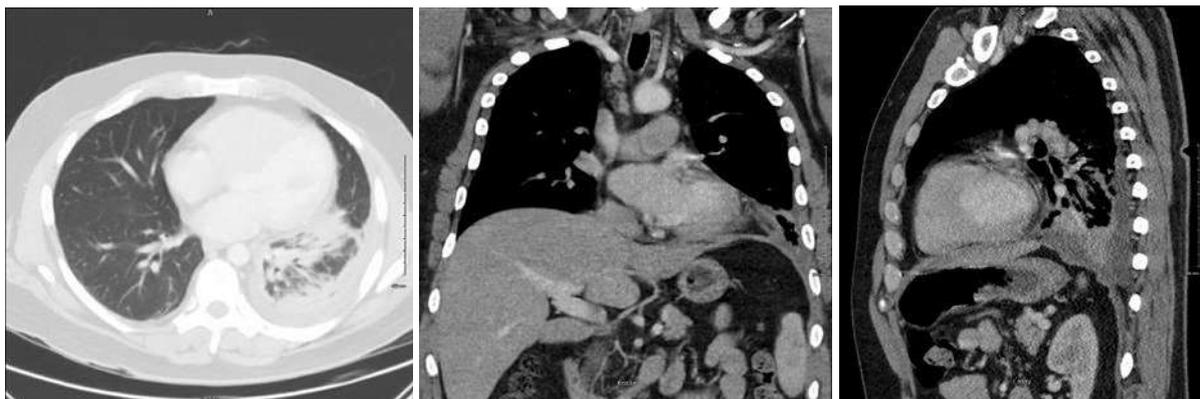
4B and 4C: Chest CT done after drainage - transverse, coronal and sagittal views - Interval near complete drainage of the cavitory lesion in the left lung base. Small residual thin curvilinear cavity remains. Airspace opacity involving the majority of the left lower lobe.
